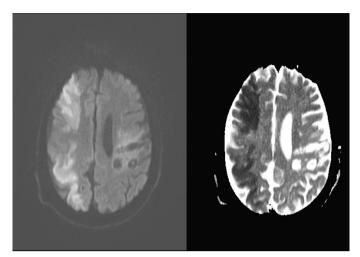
Postoperative cranial MRI image *MRI: Magnetic resonance imaging*
